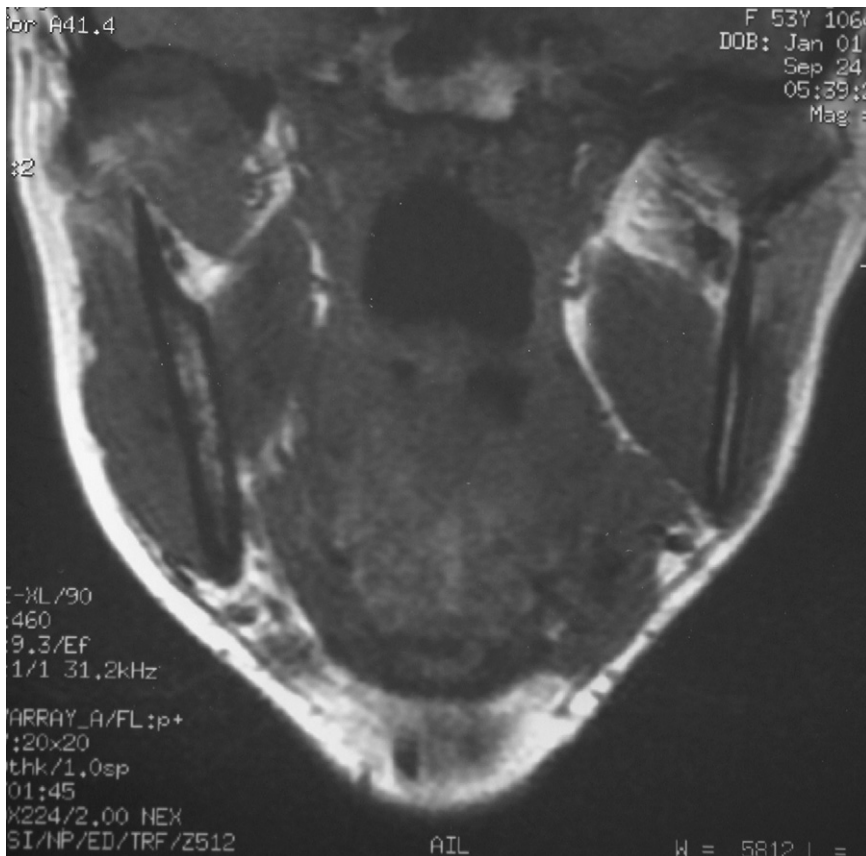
MRI showing a tumour on the left side of the floor of the mouth.
